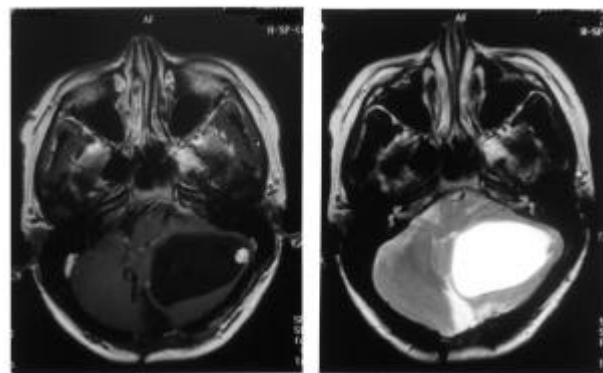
Brain-magnetic resonance imaging (MRI), at 36 weeks gestation: A) T2 weighted not enhanced, B) T1 weighted postgadolinium enhanced, showing the massive enlargement of the cystic (5.5 cm) component of the cerebellar tumour. There is left to right and posterior to anterior displacement of the brain stem.
